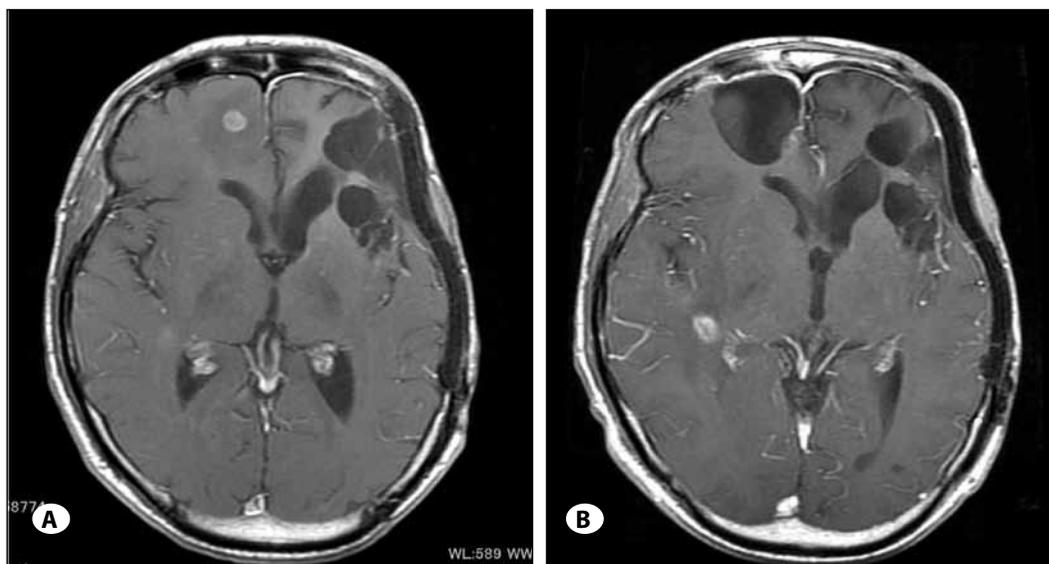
(A) Gd-enhanced axial T1-weighted MRI portrayals show (A) a homogeneously enhanced mass developing in the right frontal lobe with a perifocal edema, and (B) a homogeneously enhanced mass similar to (A) in the right posterior temporal region. (refer to Figure 1 for abbreviations).
